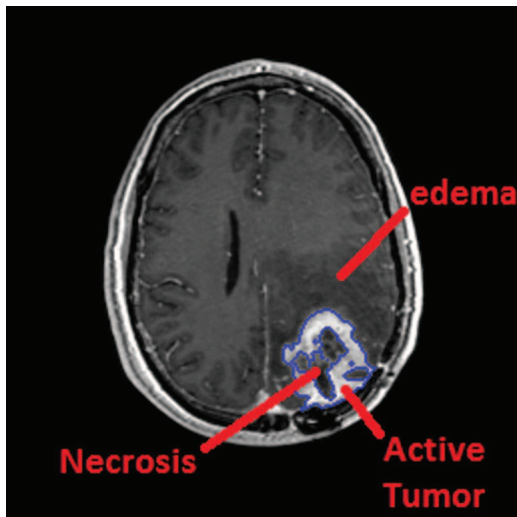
Example of a GBM brain tumor on a T1w postcontrast MR image slice with the active part contoured.
